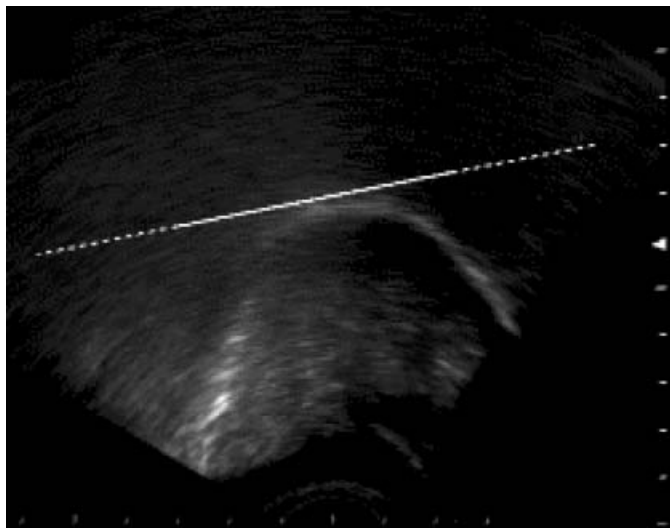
A sagittal ultrasound display of a typical adult /k/ showing an elevated tongue body. The tongue tip is on the right in all sagittal images. The reference line shows the target height for tongue back raising (and in this case, approximates the palate).
